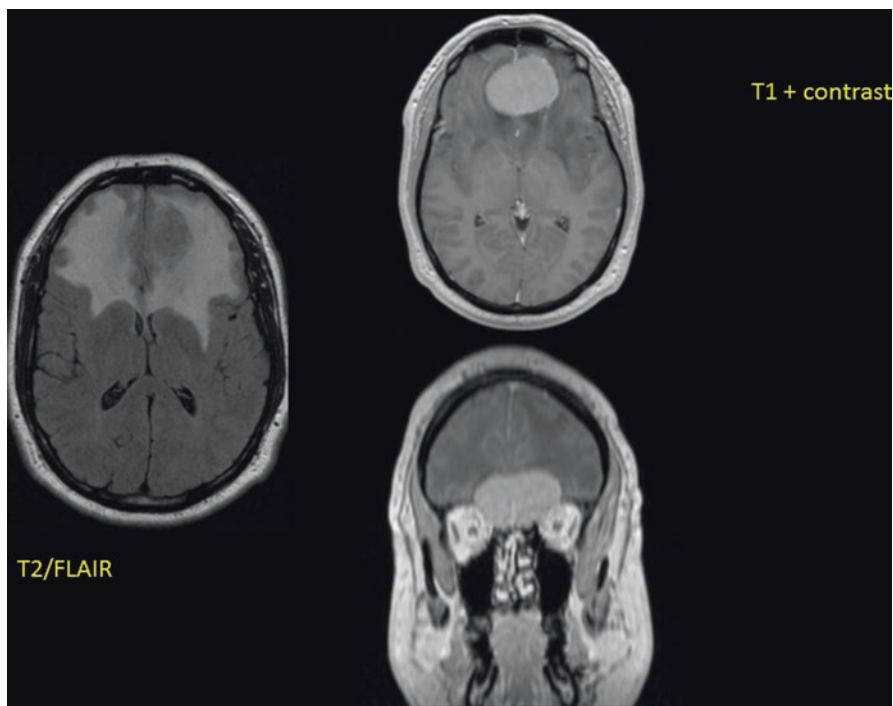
Brain MRI prior to surgery for Mr. B (Case 2). The orbital groove meningioma shows homogeneous contrast enhancement with extensive bifrontal edema, most visible on FLAIR imaging
